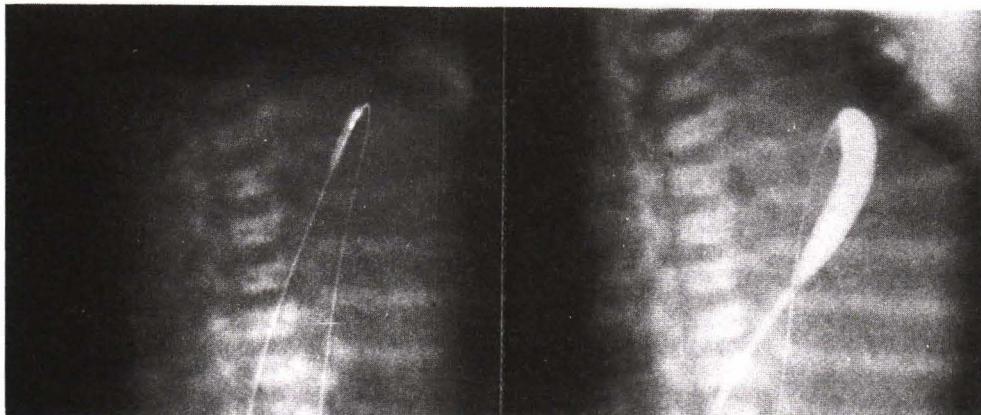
The plain films in anteroposterior view of the successful balloon dilation of the pulmonary valve with A) a 2-mm coronary artery balloon catheter and B) a 6-mm Mansfield balloon catheter.
